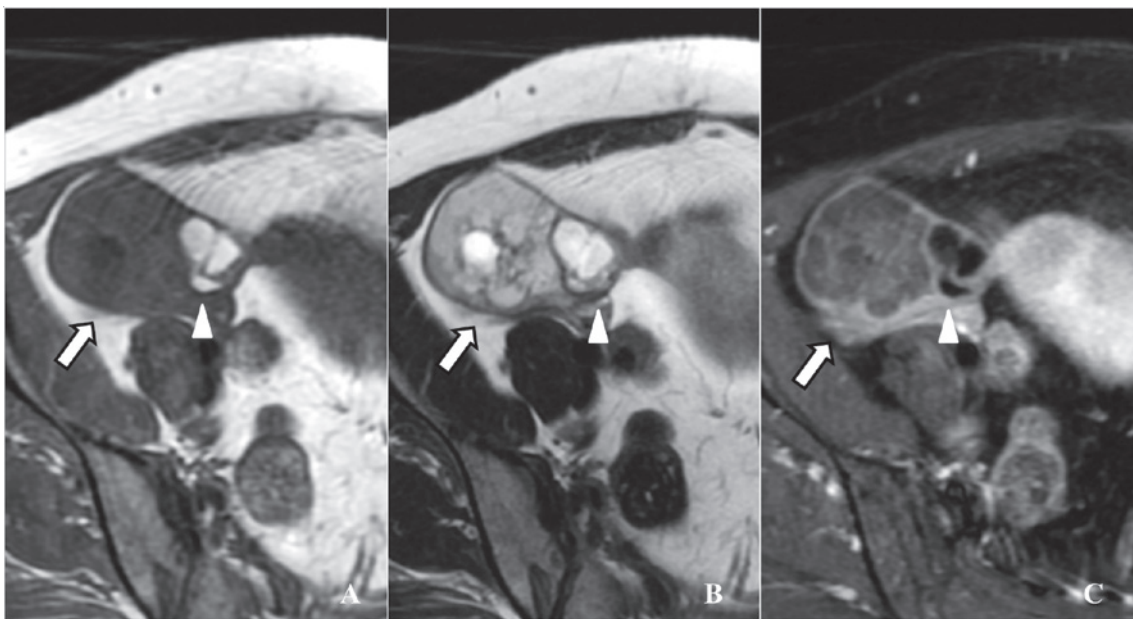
MR images: Axial T1-weighted (A), T2-weighted (B) and fat-suppressed enhancement T1-weighted (C) MR images showed a multi-cystic pelvic mass (arrow) containing fat component (arrow head). The multi-cysts showed slightly high signal intensity on T1-weighted (A) and fat-suppressed enhancement T1-weighted (C) MR images, so included mucin was suspected.
